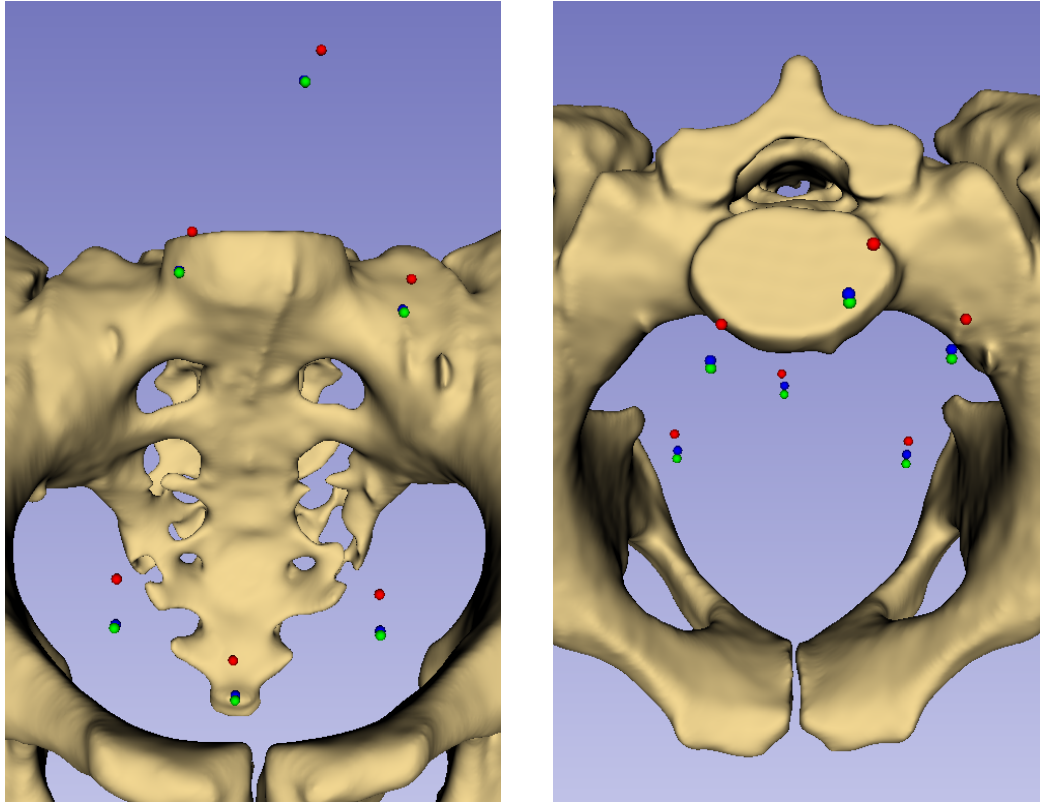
Anterior (left) and superior (right) view of the target points for patient 7 transformed to the EMTS coordinate system through CBCT registration (green), Slicer US registration in horizontal position (blue) and Slicer US registration in Trendelenburg (red). The target points have a diameter of 3 mm and the bone model was transformed with the CBCT registration.
